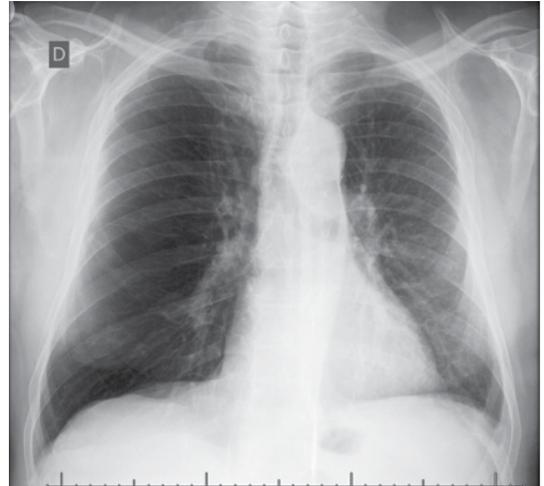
Chest X-ray of a left lung transplant recipient who underwent transplantation because of COPD.
